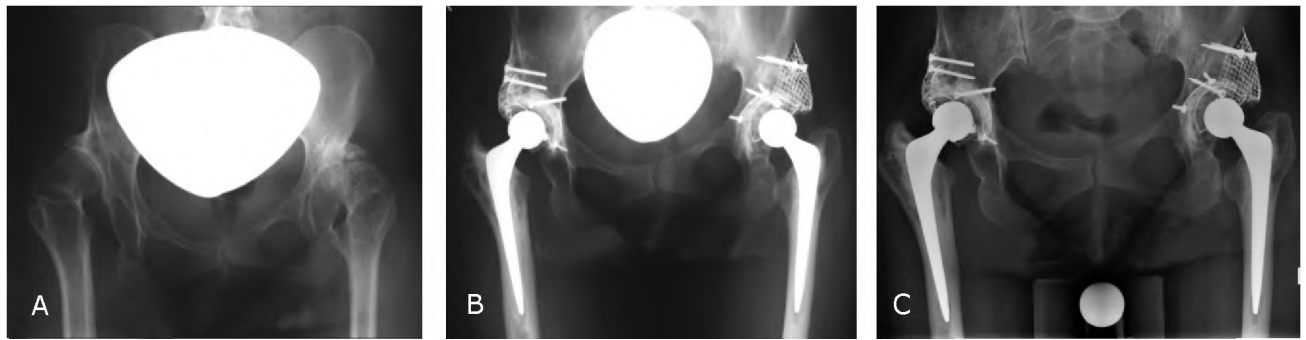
Bilateral Exeter prosthesis in a 36-year-old woman with developmental dysplasia of the hip treated with extended acetabular reconstruction with wire meshes and bone impaction grafting (A) pre-operative anteroposterior pelvic radiograph, (B) immediate post-operative view, and (C) 11 years post-operatively with a stable view of the prostheses.
